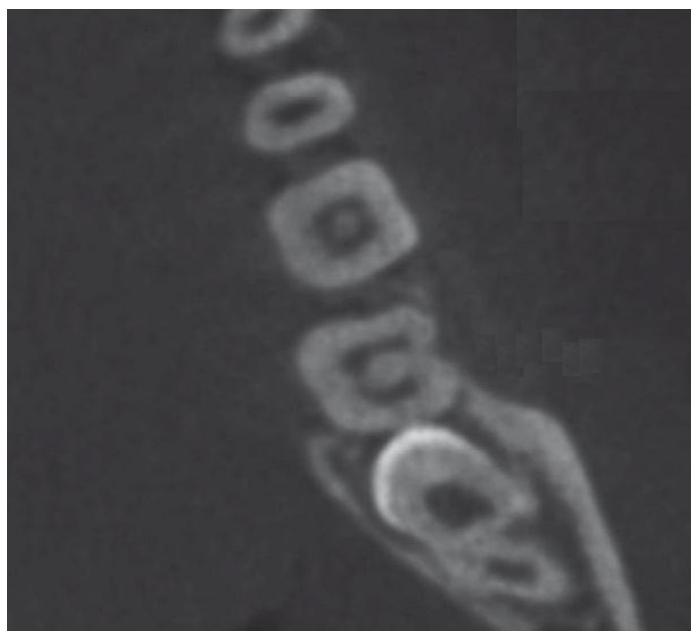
Axial view CBCT showing a C-shaped canal in mandibular 2nd molar
